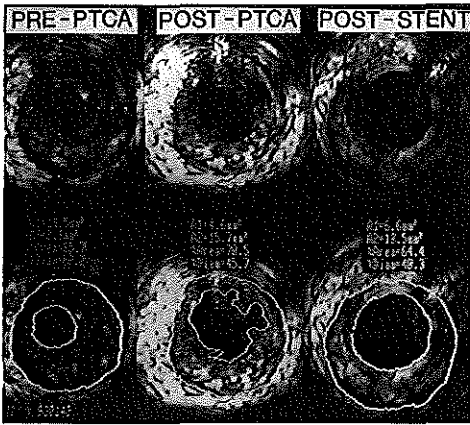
3. Ultrasound imaging prior to balloon angioplasty and following angiographically successful balloon dilatation. It can be clearly seen post-PTCA that the angiographic success is as a result of eccentric tears in the vessel wall with only a small increase in the residual luminal area (pseudosuccess). Following successful stent implantation there is a good residual luminal area. (Images courtesy of Dr. C. diMario, Thoraxcenter, Erasmus University, Rotterdam, The Netherlands.)
